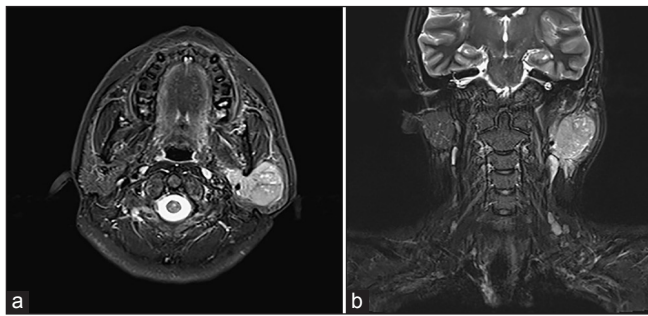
(a and b) Axial view (a) and coronal view (b) of a T2-weighted head and magnetic resonance imaging series showed an enhancing mass lesion measured about 3.9 cm × 3.5 cm × 2.7 cm in diameter in the left parotid gland, with deep lobe involvement
